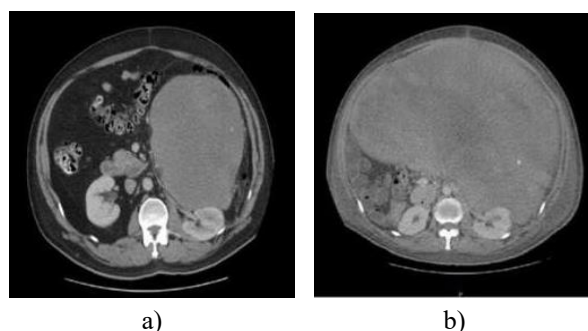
Pre-operative contrast-enhanced computed tomography (a) of the abdomen showed a large retroperitoneal sarcoma abutting the left kidney; fat planes with the left kidney and spleen were lost, and (b) post-operative imaging showing free of disease.
